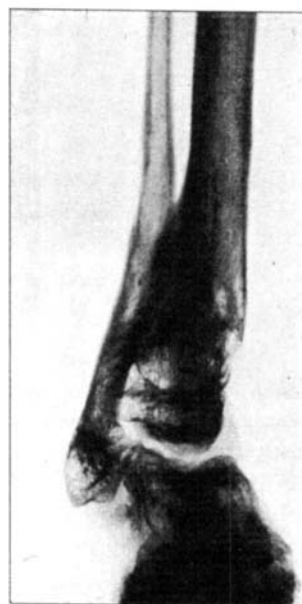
Case 3. Age eight years and five months. Radiograph taken eleven months after epiphyseodesis of the lateral malleolus.
